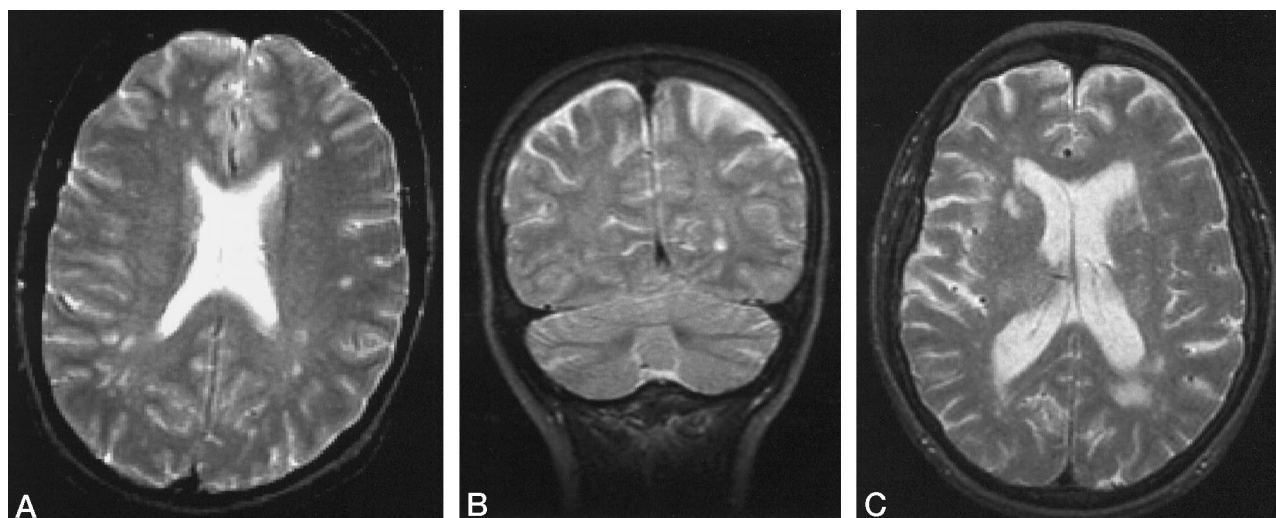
A, Patient with CNS-EMS. T2-weighted axial image (2800/80/1) of mild to moderate CNS-EMS shows minimal cortical atrophy, early ventricular dilatation, mild white matter hyperintensity, and multiple small subcortical and deep white matter focal lesions.
